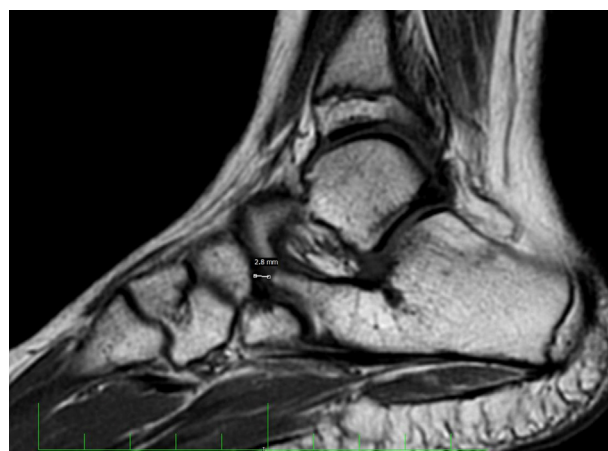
MRI; sagittal T1-weighted view: the too-long anterior process is visible. Distance from anterior process to navicular bone < 5 mm.
